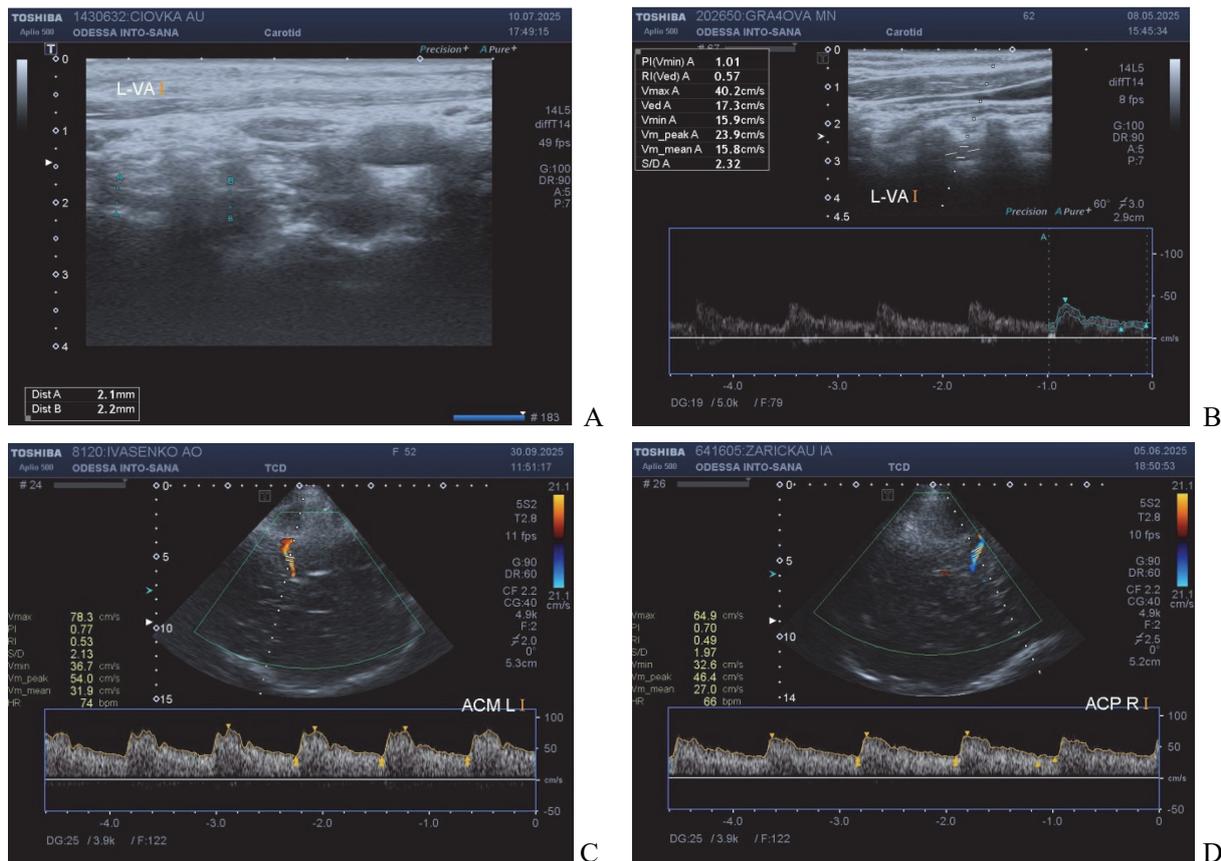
Ultrasound examination of vertebral and intracranial arteries. A – Visualization of a small-diameter vertebral artery in B-mode; B – Spectral Doppler waveform of blood flow in the vertebral artery; C – Doppler spectrum of blood flow in the middle cerebral artery; D – Doppler spectrum of blood flow in the posterior cerebral artery.
